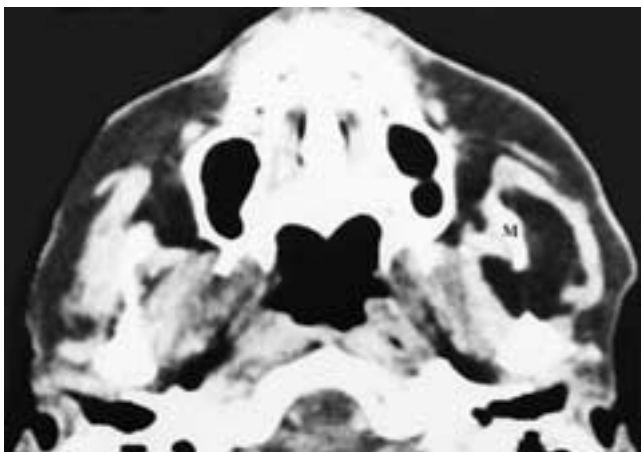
Axial CT scan shows a fat attenuation mass that has extended from the superficial portion of the left parotid gland back around the mandible (M) into the deep portion of the gland. The masseter muscle was also involved. This was an infiltrating lipoma. (From Som P, Scherl M, Rao V, Biller H. Rare presentations of ordinary lipomas of the head and neck: a review. *AJNR* 1986;7:657–664.)
